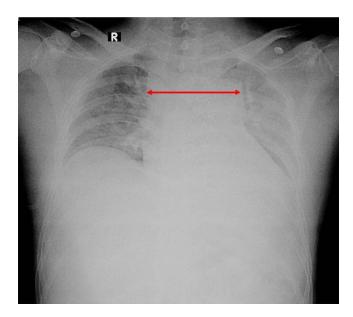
Plain chest x-ray showing the widened mediastinum associated with left pleural effusion.
